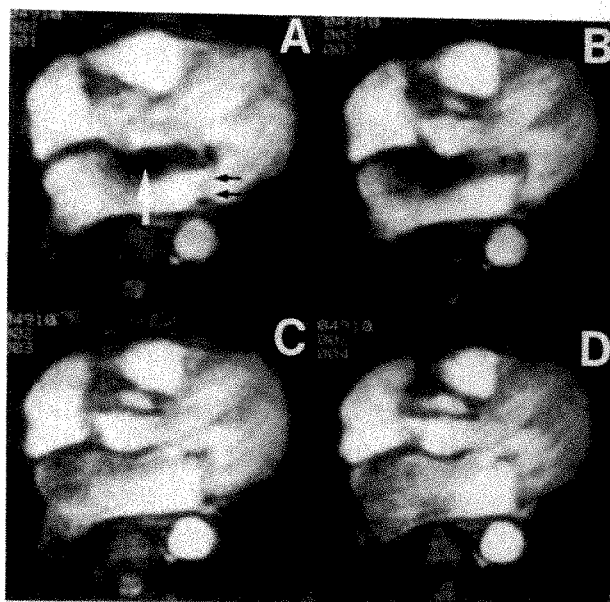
Axial systolic cine magnetic resonance images from study of a patient with severe mitral regurgitation. *A*, large white arrow points to signal void in left atrium emanating from region of closed mitral leaflets (small arrows). *B*, *C*, *D*, area of signal void enlarges and propagates medially and posteriorly throughout systole. In *C* and *D*, signal void has diminished in intensity but appears to occupy a larger percentage of the left atrial area, including pulmonary veins.
